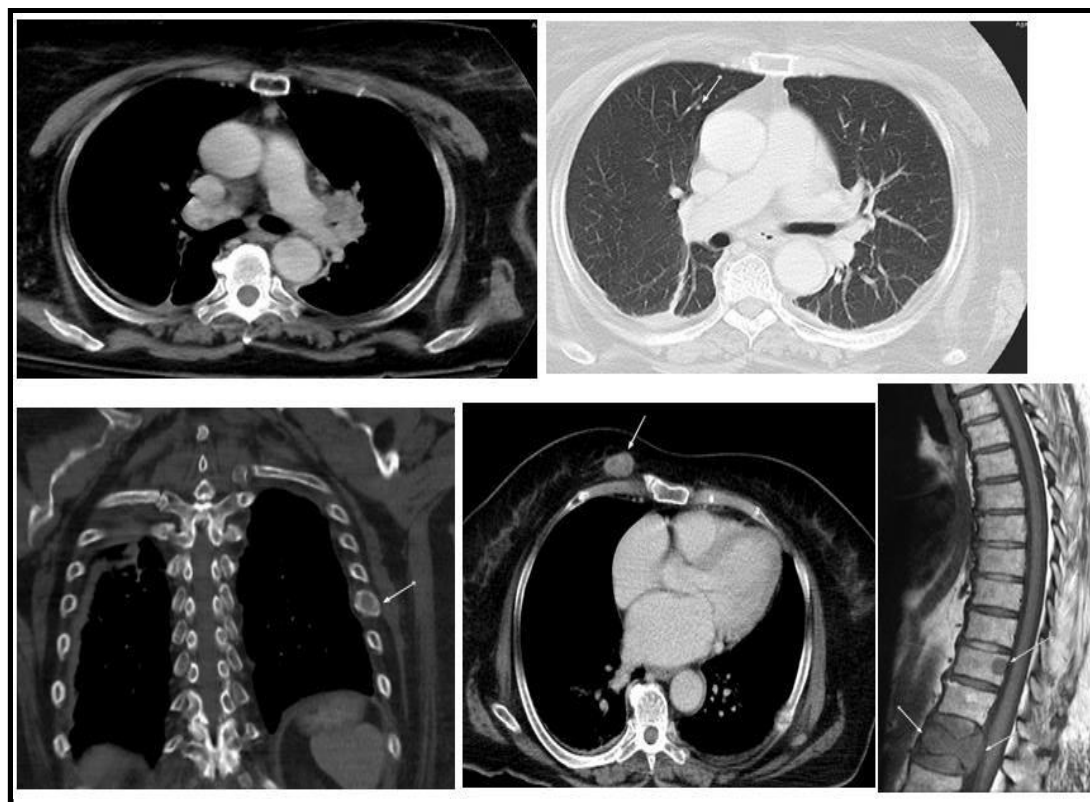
Metastatic disease including the left hilar mass, right upper lobe nodule, left rib lytic lesion, right anterior chest wall enhancing deposit and spinal deposits with lumbar vertebral collapse (MRI T1 weighted image)
